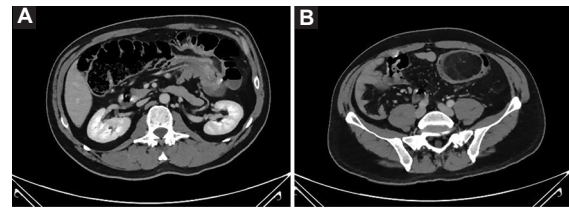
A: colo-colonic intussusception. B: colonic lipoma showing heterogeneous radiographic density.
